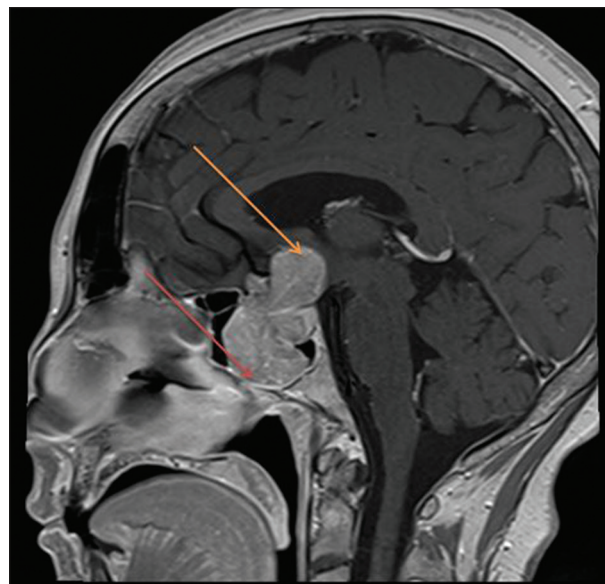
T1 post-gadolinium sagittal magnetic resonance image is demonstrating large sellar and suprasellar enhancing mass which is eroding and expanding the sellar floor and extending to the sphenoid sinus (red arrow) inferiorly and cranially it is extending to the hypothalamic region (yellow arrow)
